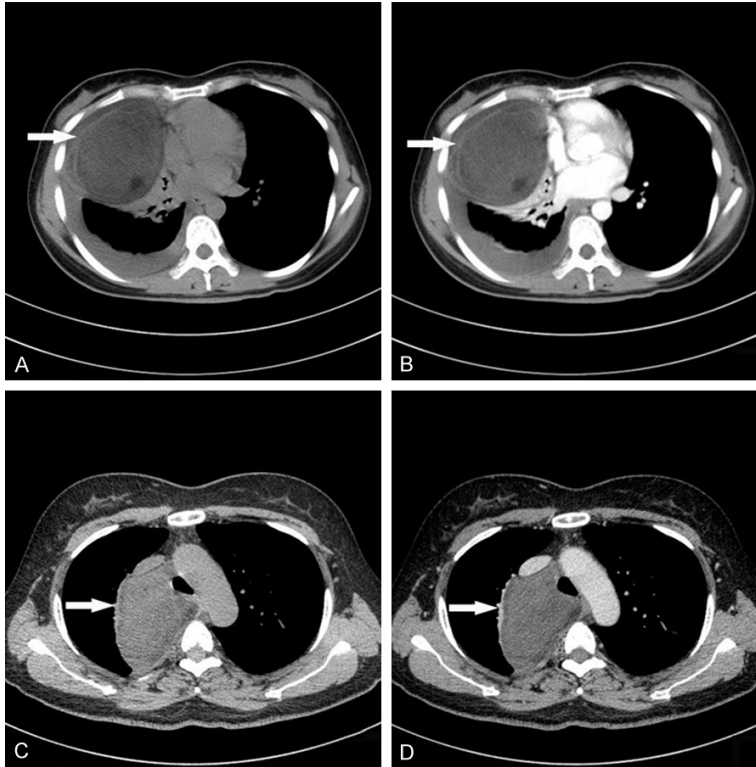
Computed tomography (CT): (A) In case one, the lesion marked with a white arrow is a large heterogeneously dense shadow in the mediastinum near the aortic arch. (B) In case one, the lesion presented as a heterogeneous density with a focal fat shadow and no distinct enhancement after contrast administration; the lesion is marked with a white arrow. (C) In case two, a distinct heterogeneously dense shadow with clear boundaries in the mid aspect of the posterior mediastinum is seen with no enhancement (D), the lesion is marked with a white arrow.
